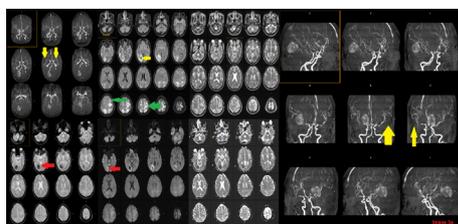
REVERSIBLE VASOCONSTRICTION SYNDROME IN PERIPARTUM ANGIOPATHY-- Axial DWI, ADC, FLAIR, T2, GRE images with reformatted MRA images showing
